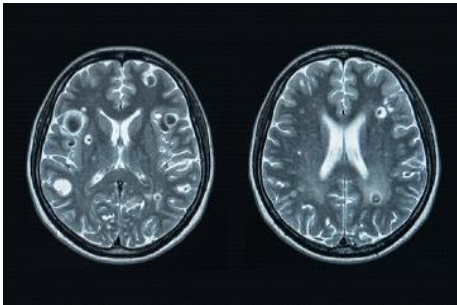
MRI finding of patient showing multiple ring enhancing lesions supporting diagnosis of neurocysticercosis
